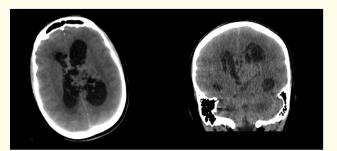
Axial (a) and coronal (b) views of a CT showing a lobulated, intraventricular mass with two components: a solid isoattenuating one and a cystic one, associated with hydrocephalus. The tumor has a broad attachment to the superior and lateral wall of the left ventricle.
